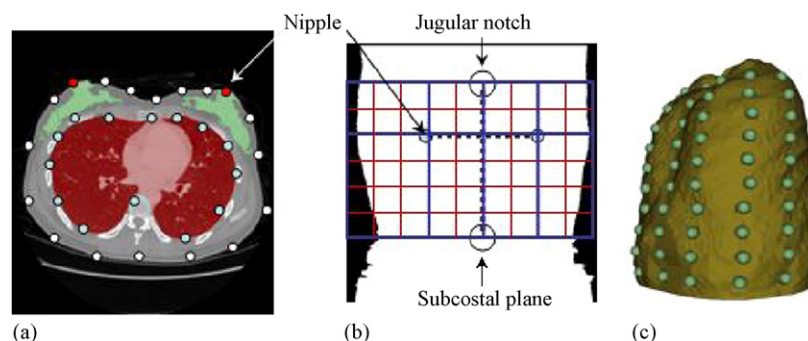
A point distribution model that shows the anatomical structure surrounding the mammary gland regions: (a) points on a slice of CT images, (b) point selections on body surface, and (c) points on surface of thoracic cavity.
